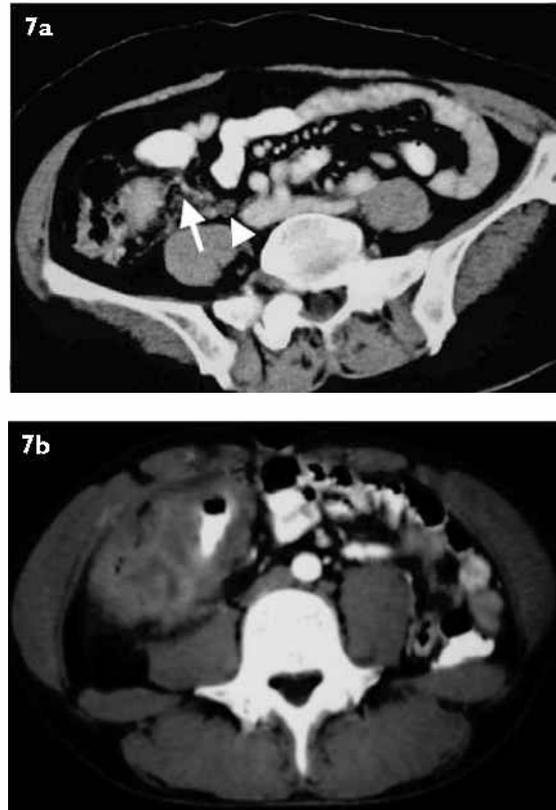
(a) Axial CT image shows TB ileocecal involvement at an early stage of the disease, thickening of the ileum (white arrow) and caecum. Regional enlarged lymph nodes may be seen (white arrowhead). (b) With disease progression, axial CT image shows the ascending colon to be thickened, resulting in mass formation and luminal narrowing in an elderly man who presented with weight loss, abdominal pain and distension. This may lead to bowel obstruction.
